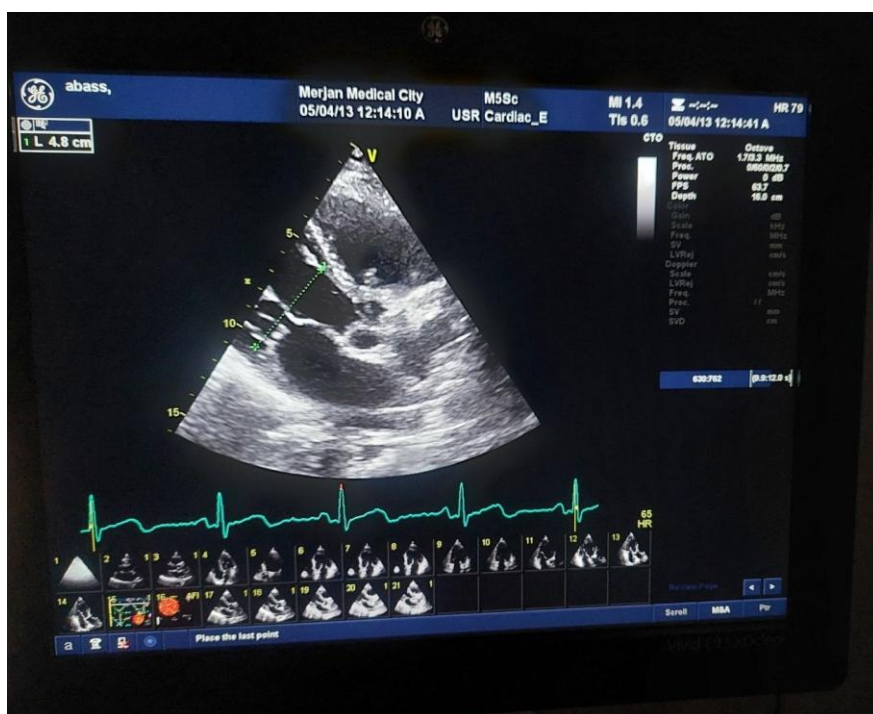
Measurement of LVDD at the end of diastole from the perspective of the parasternal long axis.
